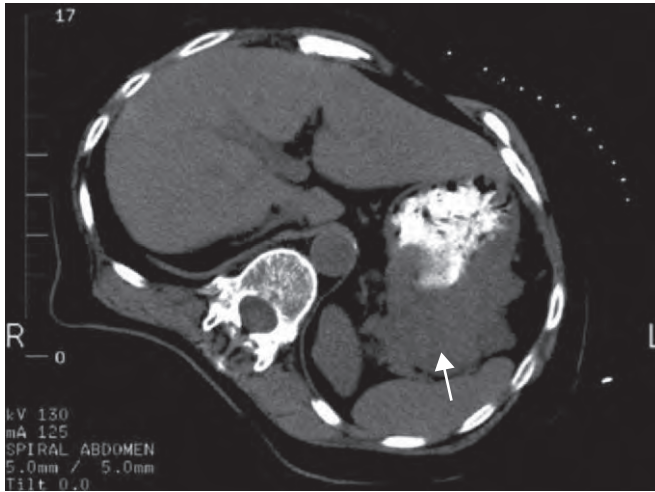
Computed tomographic scan of a primary gastric GIST (arrow). Note the extrinsic mass effect on the stomach.
